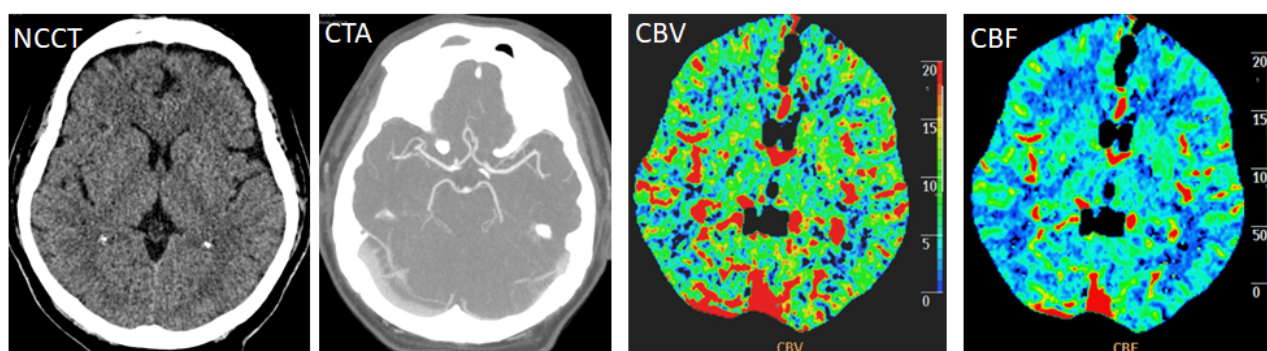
Comparative Image quality with standard radiation dose protocol and the low dose protocol for non-contrast-enhanced computed tomography (NCCT), CT angiography (CTA) and CT perfusion (CTP) in a 62 years old patient who presented with acute ischemic stroke. The top panel shows NCCT, CTA and CTP images performed using the standard radiation dose protocol. As a part of a research project, this patient underwent repeat imaging studies using the low radiation dose protocol. The resultant representative images are shown in the lower panel.
